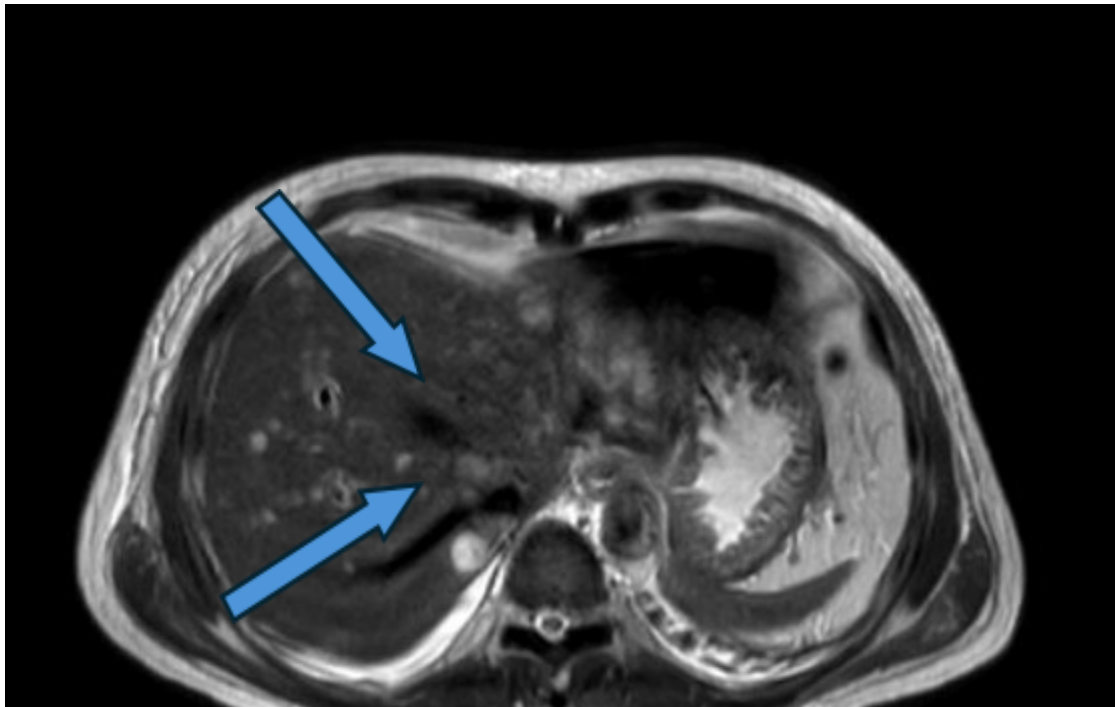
MRCP: Multiple liver lesions which have appeared over a very short span of time (previous recent ultrasound did not show a focal liver lesion). These show varying patterns of restricted diffusion and are highly suspicious of multiple liver abscesses. Features of calculus cholecystitis. Incidental intraspinal lesion. Complete MRI examination of the spine with contrast is suggested after the AKI settles. (Multiple liver lesions which have appeared over a very short span of time highly suspicious for multiple liver abscesses (Blue arrows).)
